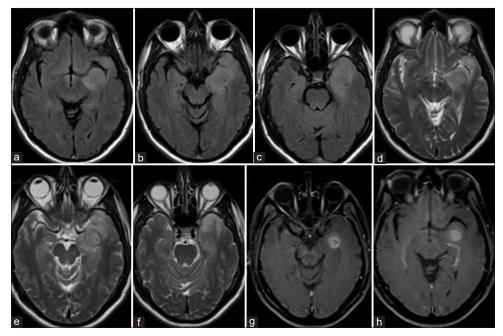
Sequential axial FLAIR (a-c), T2-weighted (d-f) and post-contrast (g and h) MRI done after 4 week showing an increase in the area of involvement of the abnormal high signal intensity in the left medial temporal lobe with new-onset ring-enhancing lesion at the site of the original abnormality in the previous MRI
